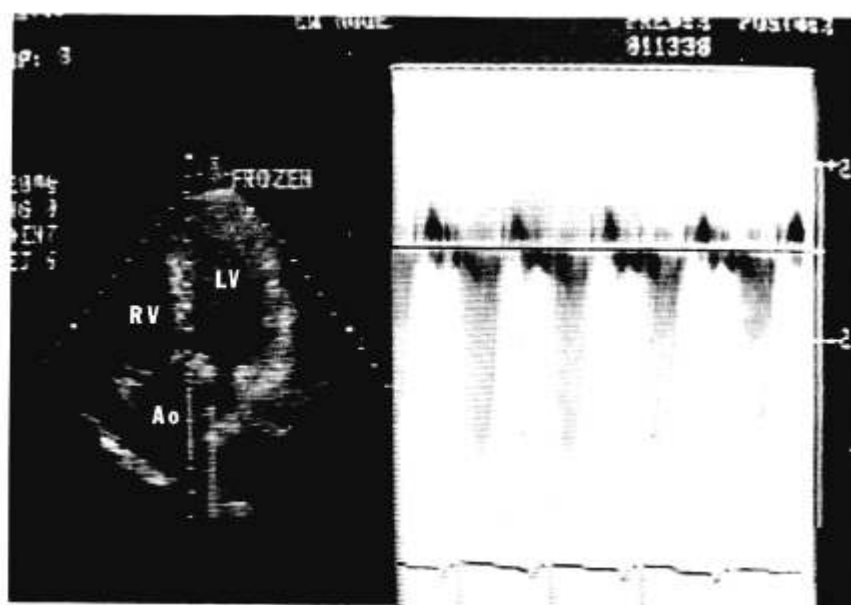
To the left, a stop-action, long-axis echocardiogram of the left ventricle. This image was produced with a precordial transducer positioned over the apex impulse. The nearly vertical white line in the aorta (Ao) marks the location of the continuous wave (CW) ultrasound beam whose reflection is analysed for the Doppler effect. This beam is positioned through the aortic valve outflow. Just right of the CW marker, a second vertical white line is an artifact emanating from the lateral edge of the heavily calcified aortic valve. To the right, the CW Doppler signal is displayed as a graph of velocity vs. time. From the formula  $\text{Gradient} = 4V^2$ , the maximum aortic gradient in this patient is estimated to be 71 mmHg where V is the maximum velocity (4.2 m/sec) shown in the graph. LV is left ventricle and RV right ventricle.
